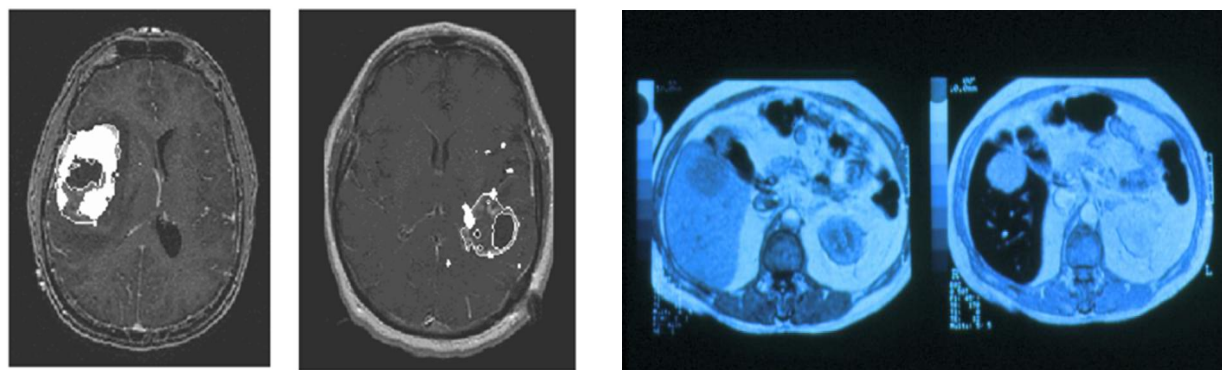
MRI images before (right) and after (left) injection of a contrast agent, in a GBM-affected brain. (a) MRI image using a Gd^{3+} chelate as a contrast agent. Affected part is shown brighter than its surroundings. (b) MRI image using USPIO as a contrast agent. Affected part is shown darker than its surroundings.(34)
